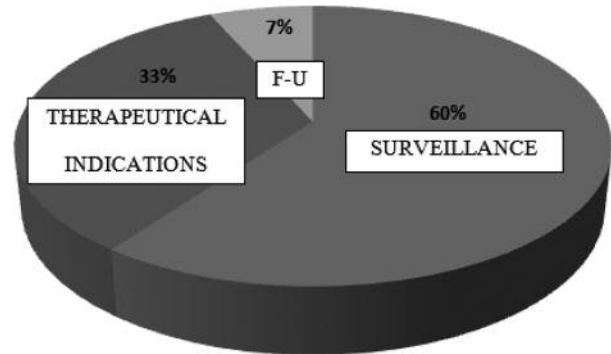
Main indications for mp-MRI in Sant'Anna Hospital, Como, Italy.
